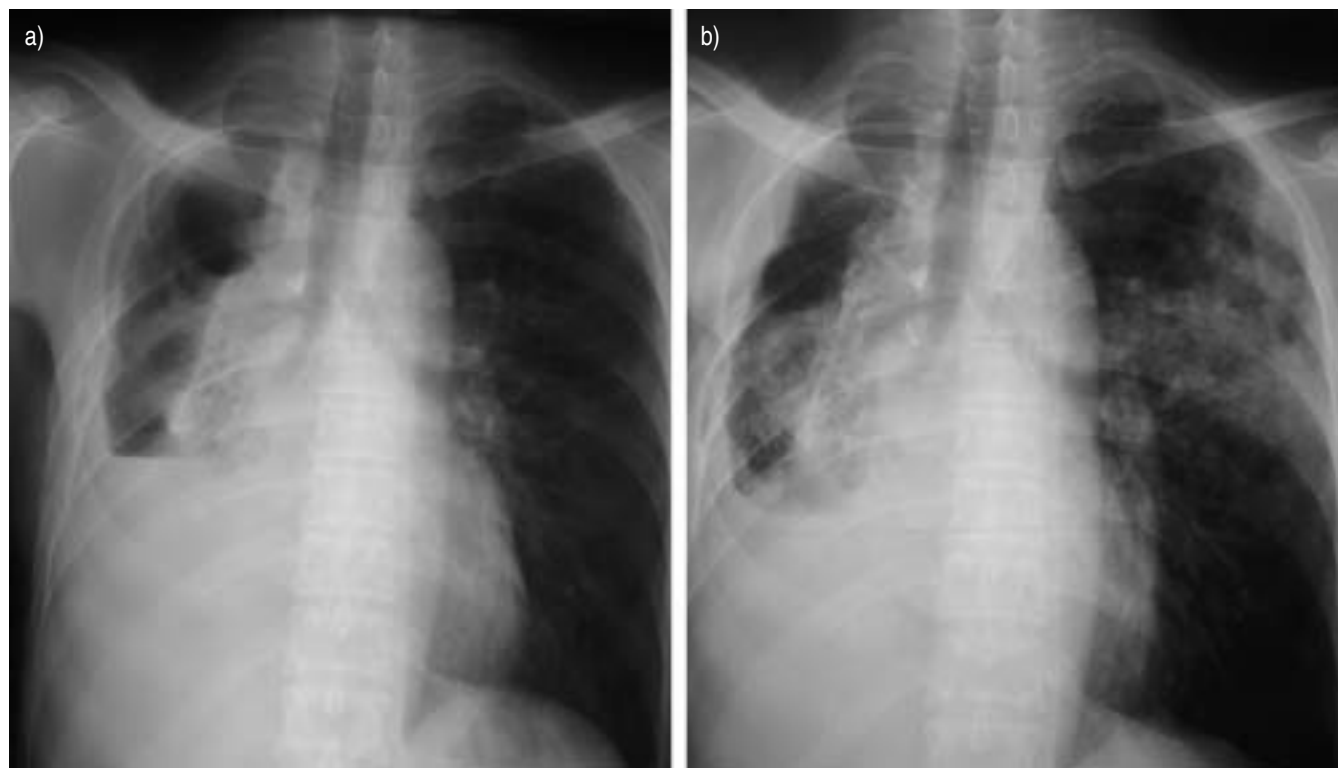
Chest radiographs on a) diagnosis of empyema and before thoracostomy (November 1999) and b) admission (January 2001).
